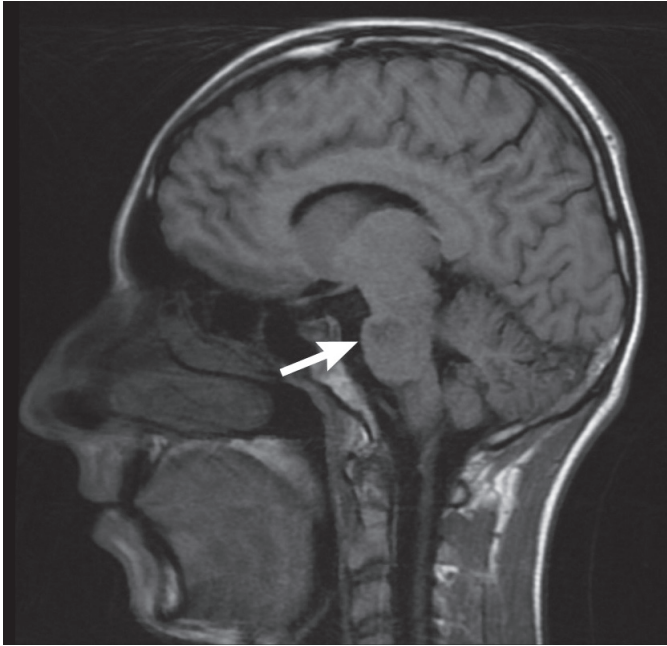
Magnetic resonance imaging – fluid attenuated inversion recovery, sagittal plane: acute infarction in the pons.
